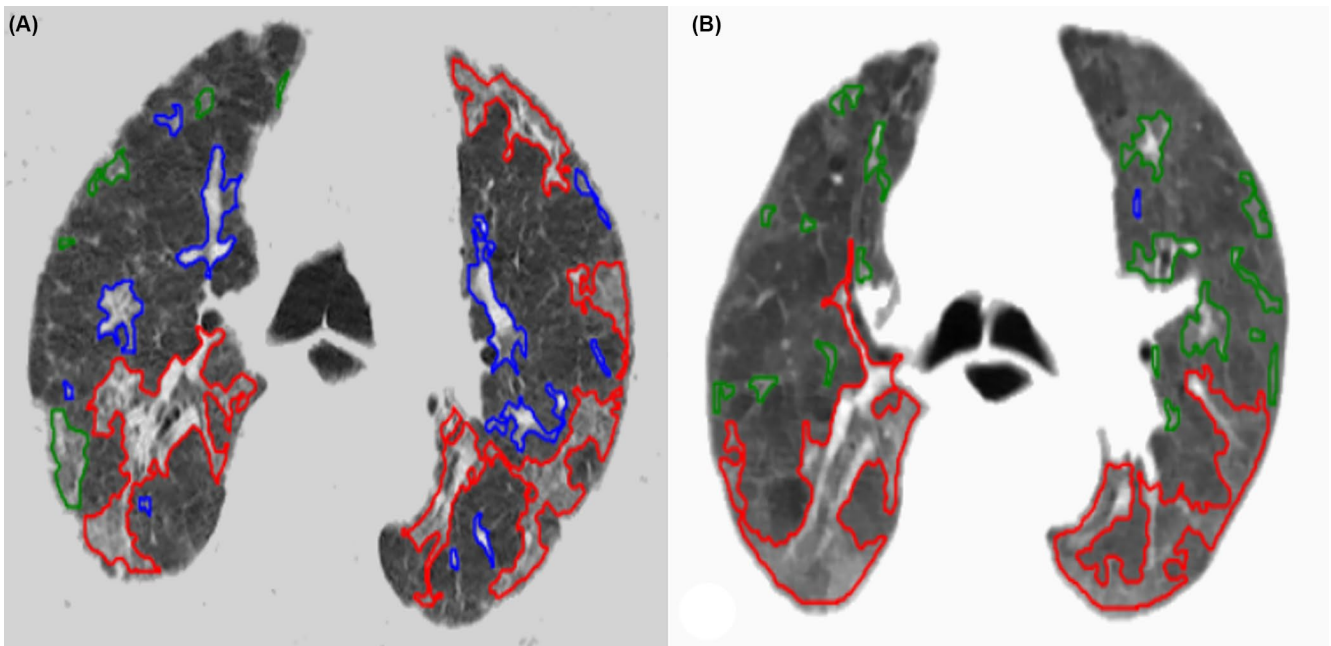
A male patient on methylprednisolone therapy; There is a slight decrease in the rates of lung involvement in CT images passing at the same level before (A) and after treatment (B)
